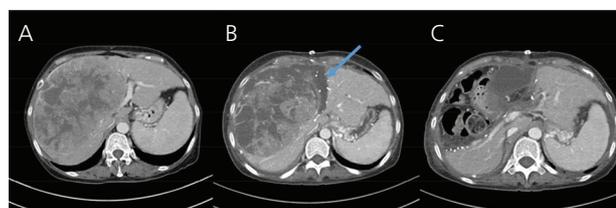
(A) preoperative CT shows that huge HCC (>20cm) compresses of right glisson; (B) CT between 1st stage and 2nd stage operation shows increased volume of left lateral section and the partition between left lateral section and S4 (blue arrow); (C) CT after 2nd stage operation shows successful central hepatectomy.
